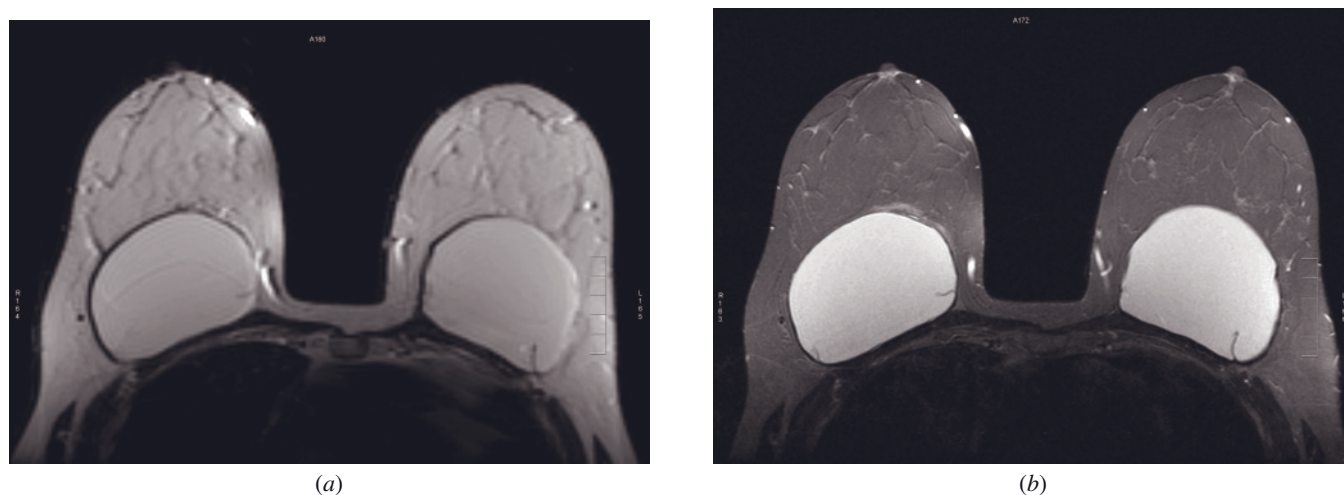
Silicone implant extracapsular rupture. Axial T2-weighted (*a*) and axial short tau inversion recovery (STIR) with chemical saturation of water-silicone specific (*b*) images show bilateral subglandular implants. Radial folds are seen bilaterally (*b*) as curved hypointense lines, perpendicular to the capsule (posterolateral aspect of the left breast implant and medial aspect of the right breast implant). In anteromedial aspect of the right breast implant a subcapsular line is seen, indicating implant rupture. Ill-defined, high-signal anterior to the implant and adjacent to it corresponds to extracapsular silicone, best appreciated in *b*.
